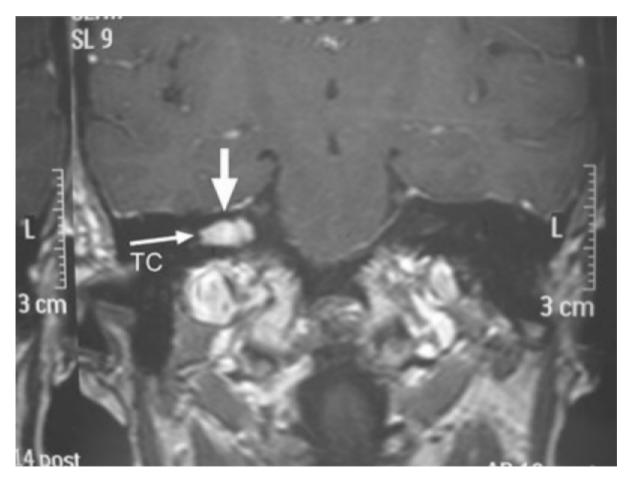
T1-weighted magnetic resonance image with contrast showing a right internal auditory canal acoustic neuroma located laterally in the fundus (*arrow*), above and below the transverse crest (TC).
